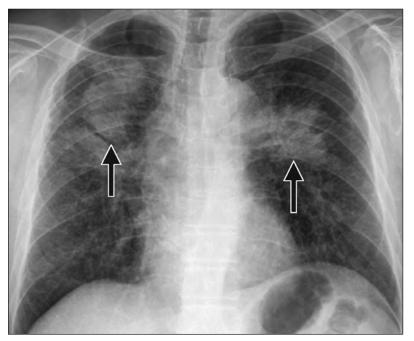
Chest radiograph in a 60-year-old coal worker showing bilateral mass lesions (arrows) in the upper lungs with fibrotic change. The "angel's wing" appearance suggests progressive massive fibrosis.
